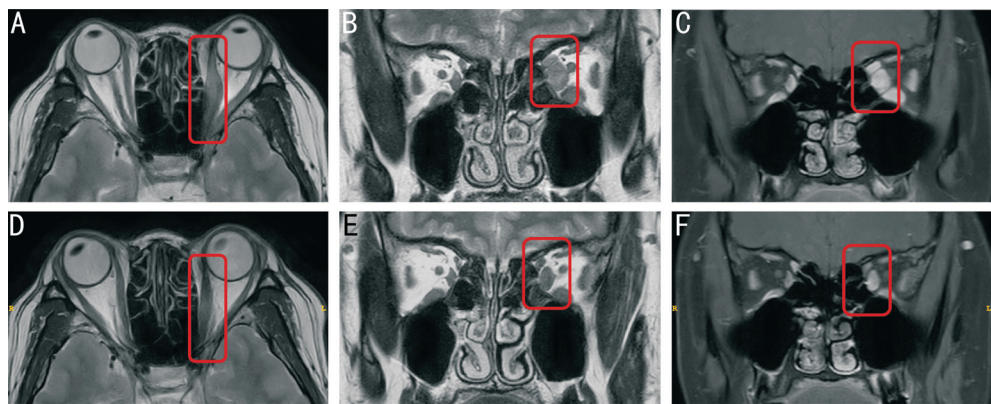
Comparison before and after treatment in MRI images of the patient It includes T2-weighted transverse images A and D, T2-weighted coronal images B and E, and T1-weighted coronal images with fat suppression C and F. A, B and C: The condition before treatment; D, E and F: The condition one month after completing four doses of therapy. The red box indicates the primary muscle involvement, showing the left medial rectus muscle before and after treatment. MRI: Magnetic resonance imaging.
